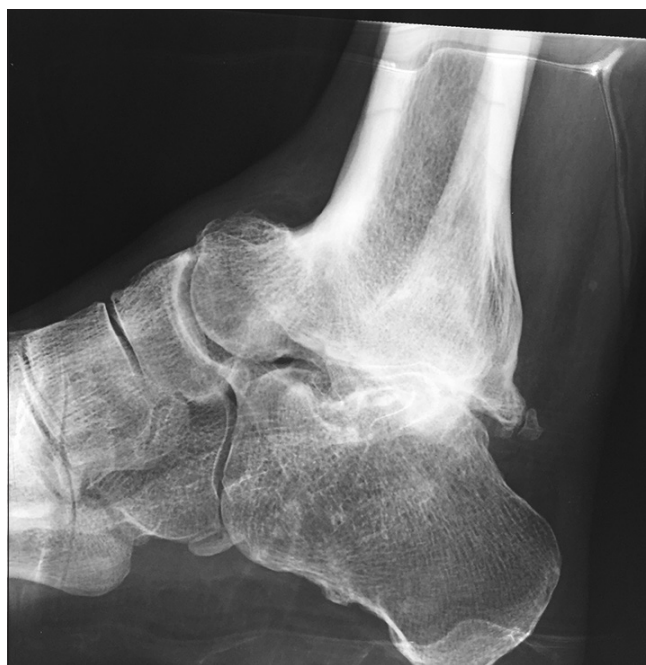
X-ray ankle joint lateral view of 20 year long term followup showing that Blair's Fusion done by excision of talar body and anterior tibial sliding Graft after which the patient recovered and currently is working as a Restaurant manager in Australia
